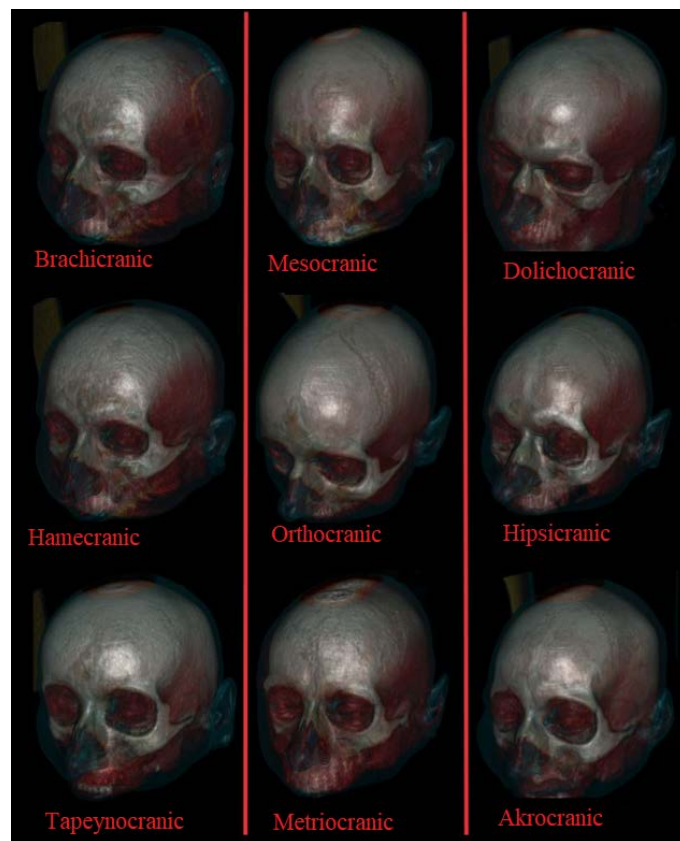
Types of the skull structure of a mature person (CT No. 2002-16; CT No. 1992-16; CT No. 1914-16; CT No. 1914-16; CT No. 1998-16; CT No. 2019-16; CT No. 1851-16; CT No. 1983-16; CT No. 2123; CT No. 1938-16).
